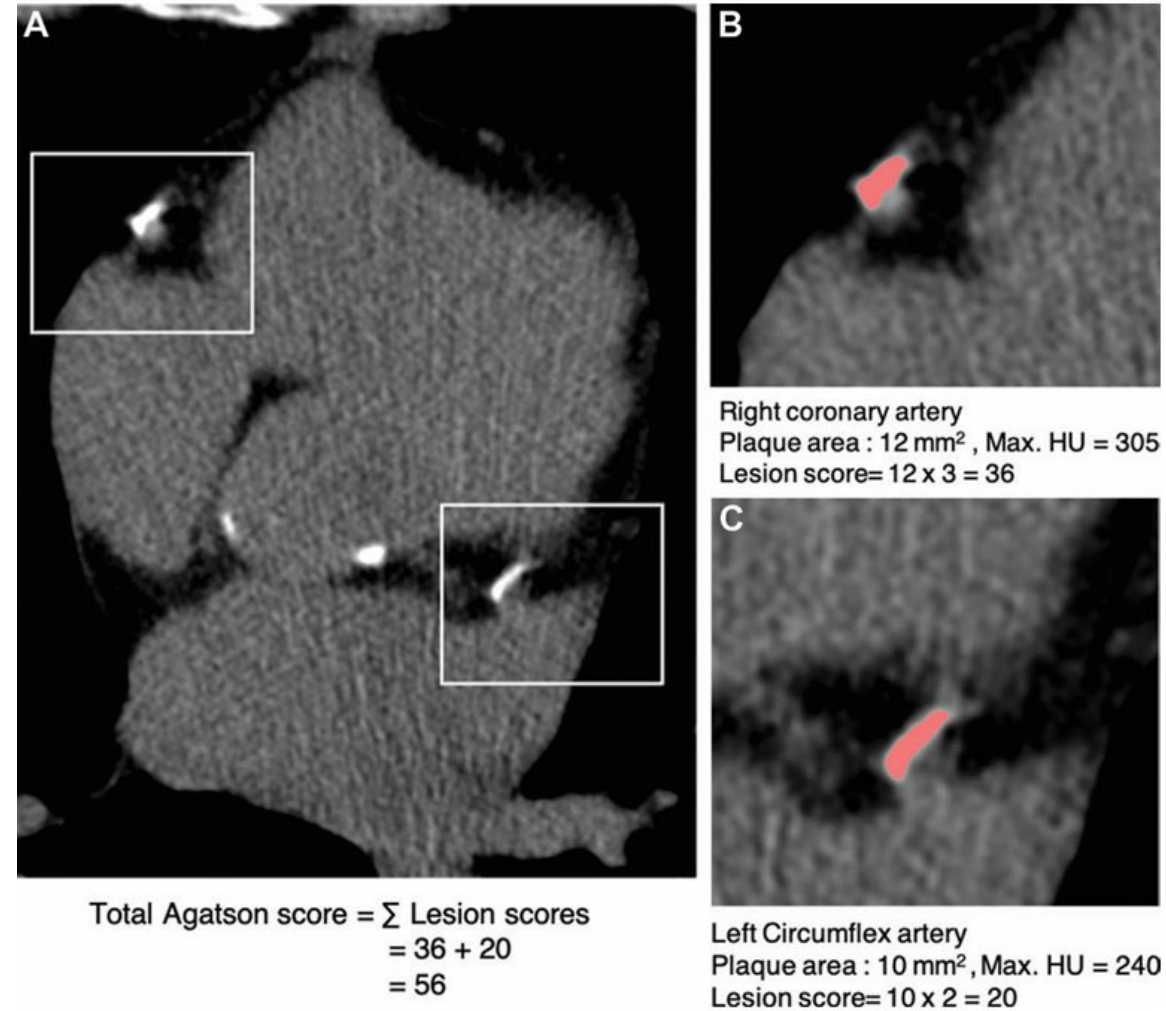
Agatston CAC score calculation in a 53-year-old man. After CT scan acquisition, the coronary artery calcifications (square outlines in A, red areas in B and C) are segmented by using a semiautomatic method in the vendor-provided software. The software also provides plaque area and maximal plaque attenuation values, which when multiplied by the attenuation weighting factor yield the calcium score for the plaque. The individual scores of all the coronary plaques are then added and reported as a single number (56 in this example).
